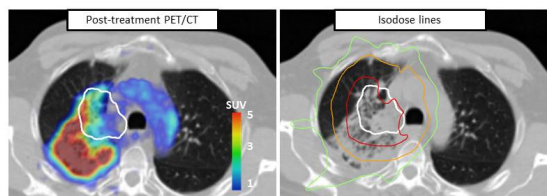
Sample patient. The left image shows an axial slice of a post-treatment FDG PET/CT scan, while the image on the right displays the isodose lines (green = 45 Gy, orange = 60 Gy, red = 75 Gy) on the post-treatment CT scan. The primary tumor (outlined in white) demonstrates marked anatomic and metabolic regression. An area dorsolateral of the tumor shows discernable FDG uptake indicating an inflammatory response to lung tissue damage. The patient clinically had grade I pneumonitis.
